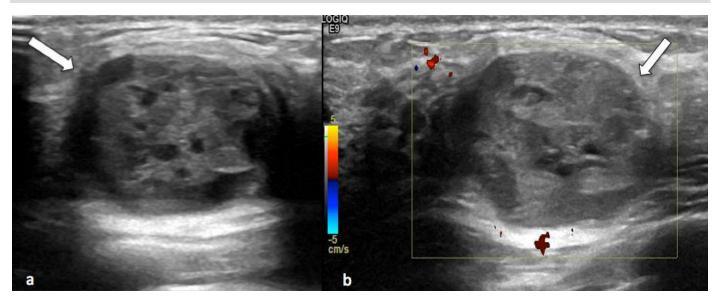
29 year-old female with metaplastic breast carcinoma. a) FINDINGS: Initial diagnostic sonogram of the patient's palpable breast mass demonstrating the metaplastic breast carcinoma presenting as a 1.8 cm oval mass (white arrow) with posterior acoustic enhancement. TECHNIQUE: 16MHz linear transducer gray-scale sonographic image. b) FINDINGS: Color Doppler image of initial diagnostic sonogram demonstrating the metaplastic breast carcinoma (white arrow) without significant increased internal vascular flow. TECHNIQUE: 16MHz linear transducer color Doppler sonographic image.
